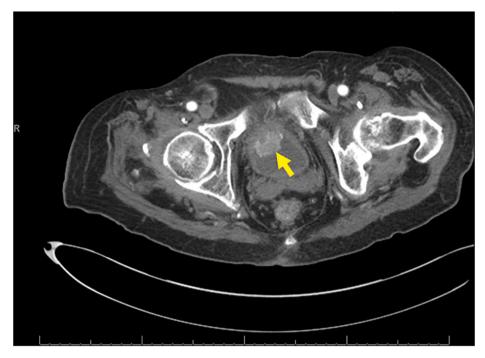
Axial contrast-enhanced CT image through the pelvis shows a lobulated, enhancing soft tissue mass arising from the right anterior, inferior bladder wall and protruding into the lumen (arrow).
